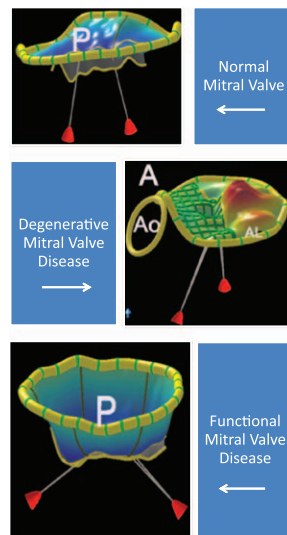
Peak systolic parametric mitral valve maps derived from 3-dimensional echocardiographic images. Parametric map of a normal mitral valve positioned to visualize the leaflet coaptation area and location of the papillary muscles below the valve annulus (top row). The color on the parametric maps indicates the degree of leaflet displacement into the left atrium from the mitral annulus. With degenerative mitral valve disease, the parametric map (middle row) demonstrates prolapse of the P1 and P2 scallops (orange color). With functional mitral regurgitation, the parametric map (bottom row) demonstrates a dilated annulus with loss of the normal saddle shape and tenting of the leaflets, preventing their motion back to the annular plane. AL indicates anterolateral; Ao, aortic annulus; and P, posterior.
